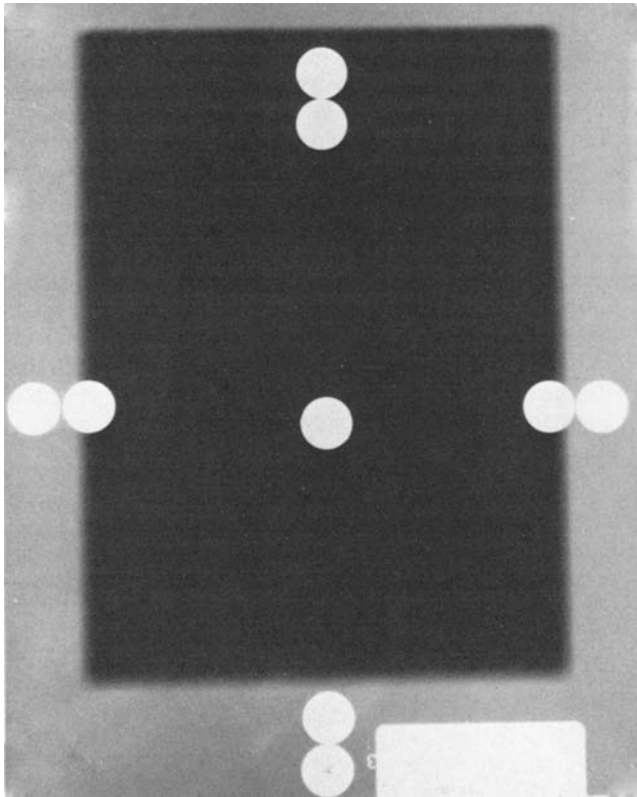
Radiograph of the markers used to measure X-ray–light field congruence. The fields were severely misaligned in this image.
